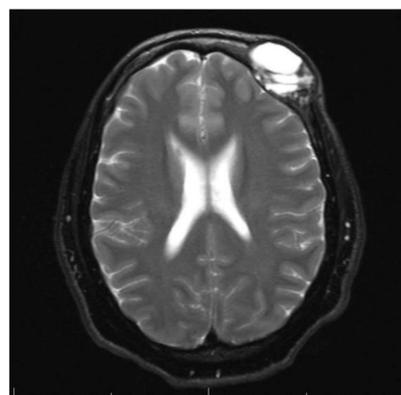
Axial T2 MRI brain demonstrating a heterogeneous lesion with both cystic and solid components
